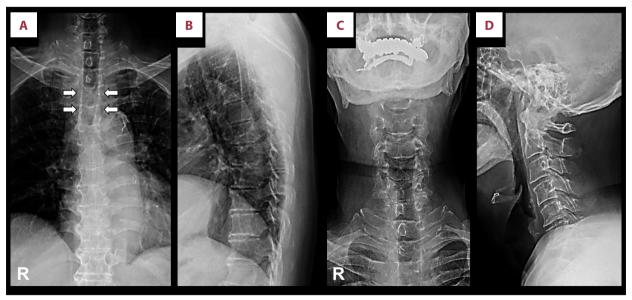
Preoperative radiographs showing osteolytic lesion at T3 and T4. (A) A posteroanterior radiograph of thoracic spine with bilateral winking owl sign at T3 and T4 (white arrows). (B) A lateral radiograph of thoracic spine. (C) A posteroanterior radiograph of cervical spine. (D) A lateral radiograph of cervical spine.
